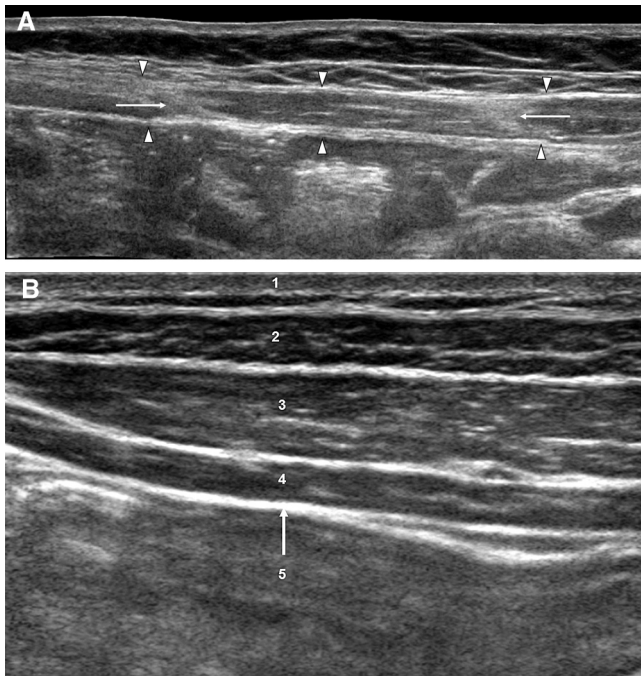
(A) Normal anatomy of anterior abdominal wall; extended field-of-view image; normal rectus muscle (arrowheads) is hypoechoic, with strands of internal echogenicity that extend from the pubic symphysis—crest inferiorly to the xiphisternum and adjacent costal margin superiorly; the compartment is divided by tendinous intersections, which appear as linear echogenic lines on ultrasound (arrows). (B) Normal anatomy of the abdominal wall laterally; transverse sonogram on the lateral abdominal wall; the peritoneum is marked by the arrow. 1 = skin and subcutaneous layer; 2 = external oblique muscle; 3 = internal oblique muscle; 4 = transversus abdominis muscle; 5 = peritoneal cavity.
